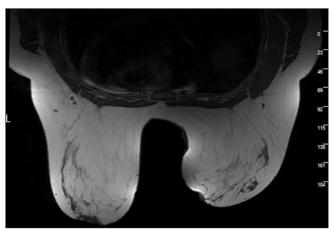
Pre-contrast fat-suppressed T1-weighted images in Magnetic Resonance imaging (MRI) of hamartoma showing a hyperintense fatty signal
